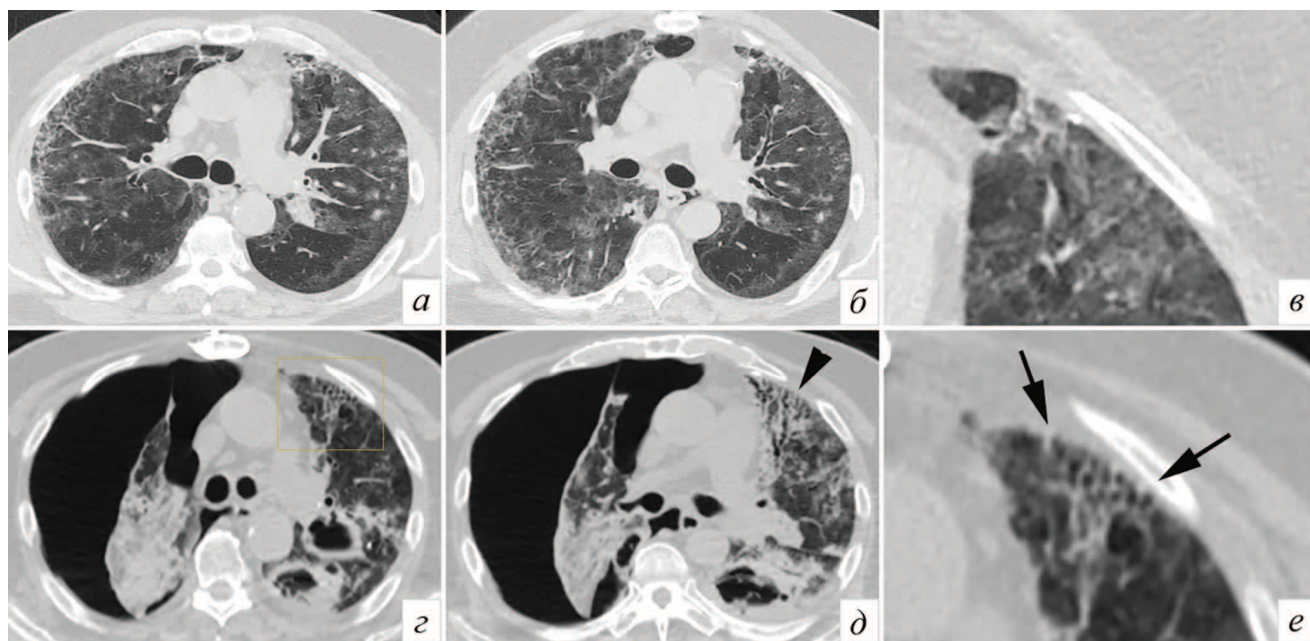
Patient M., 65 years old. COVID-19 (PCR+). Thoracic CT scans in the axial projection (a-e) with enlarged fragments (b, e) at the corresponding levels. The top row — the study dated 08/04/2021, the bottom row — the study dated 09/16/2021. Secondary infection (cavities) and pneumothorax on the right, in S3 on the left there is an area with varicose broncho- and bronchiolectasia (arrow head), as well as an area similar to a “honeycomb” deformation (frame, arrows)
